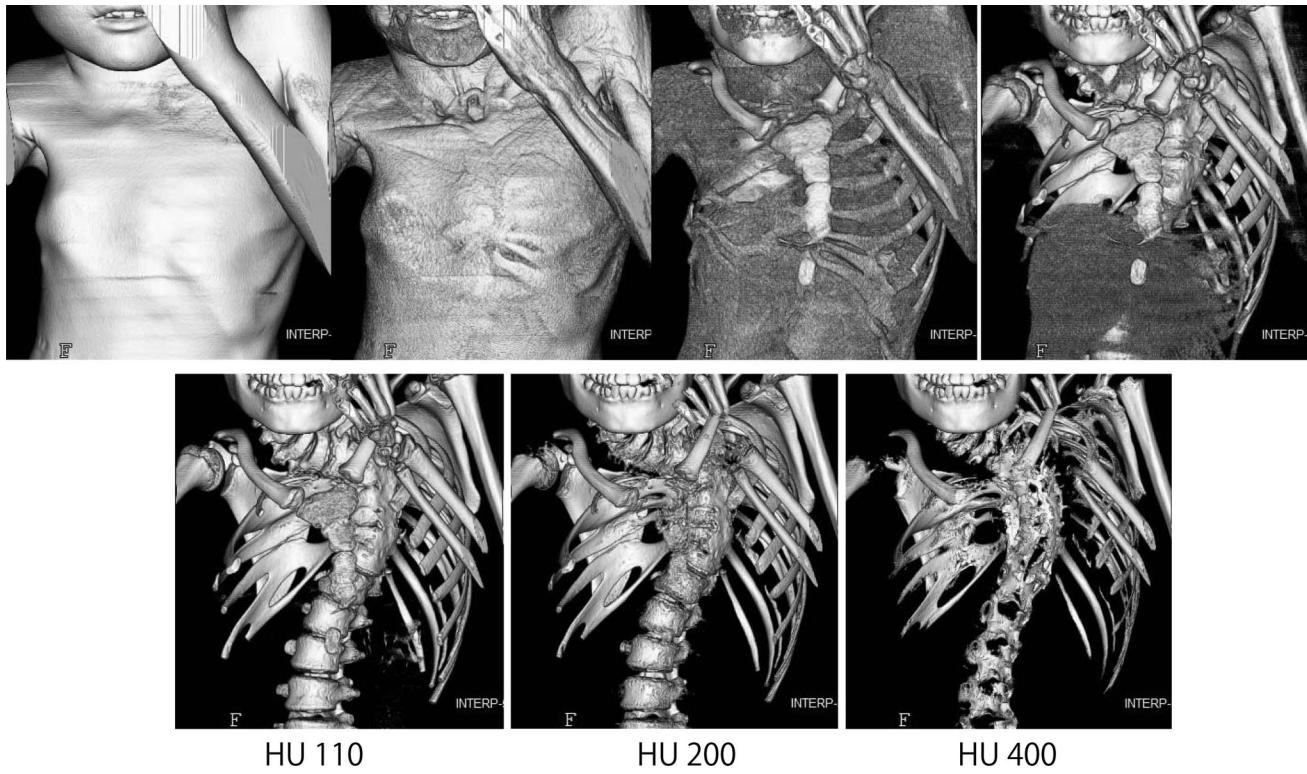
The process of reconstruction of 3D CT images. During processing a reconstruction image of the bony skeleton, not bony structure are erased gradually following masking of the soft tissue. An image demonstrating the vertebrae and ribs without erasing the bony structure can be obtained at step of Hounsfield unit 110.
